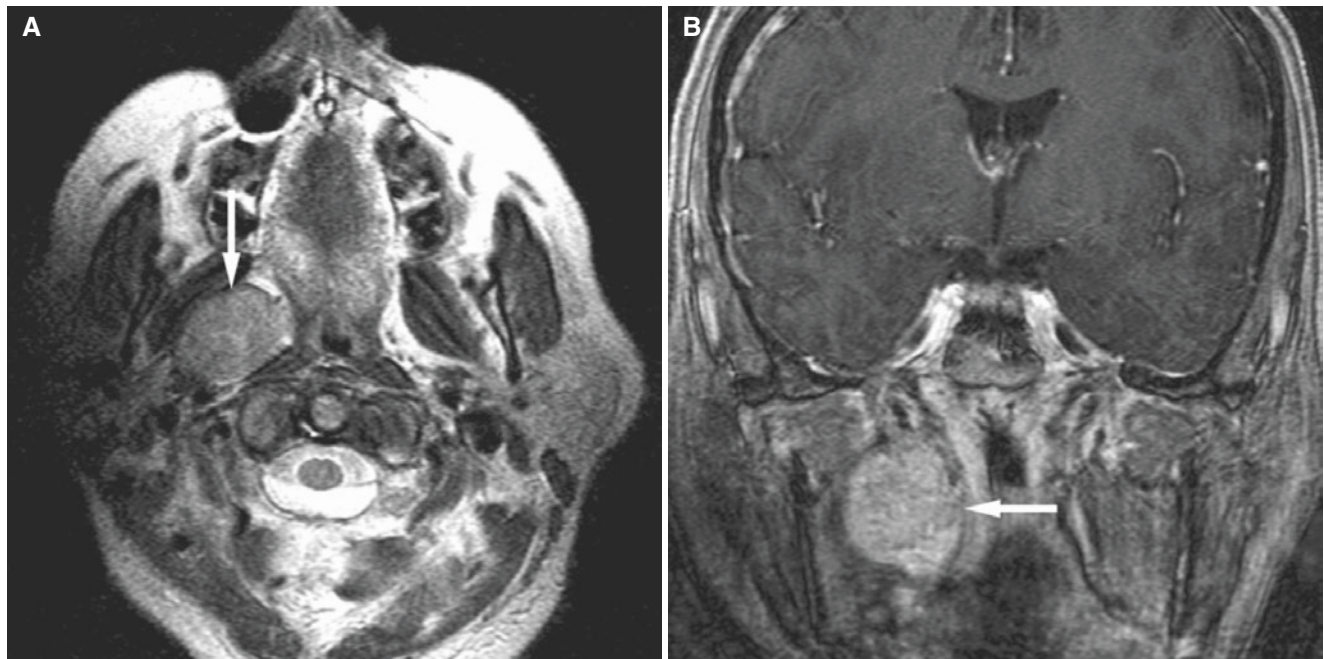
CT fluoroscopy-guided biopsy of parapharyngeal mass. (A) Axial T2-weighted MRI shows deep parapharyngeal mass (*arrow*). (B) Coronal T1-weighted post-Gd MRI shows mass (*arrow*) medial to the ramus of the mandible. (C) Patient placed in lateral decubitus. Markers, white dots, are placed on the skin to guide an oblique posterior
